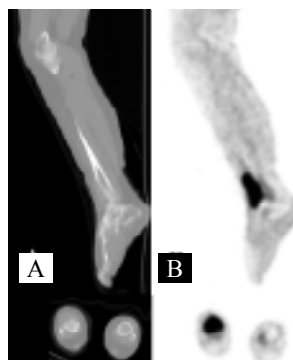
Sagittal and transaxial (A) CT and (B) PET images through right tibia indicating focal ¹⁸F-FDG uptake in a lytic lesion due to metastatic MM.
